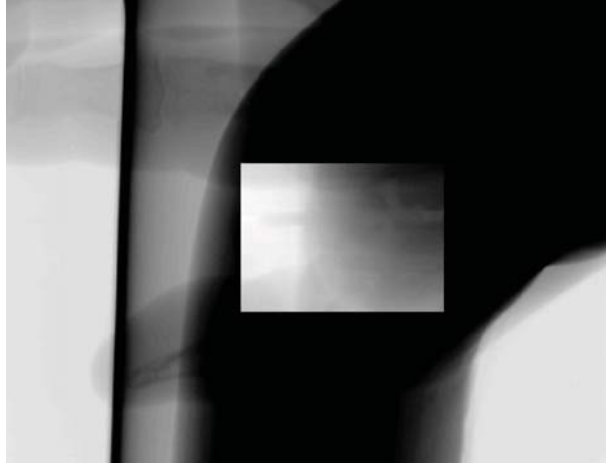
In this figure the truncation correction map of a distinct X-ray CBCT projection image is presented.
